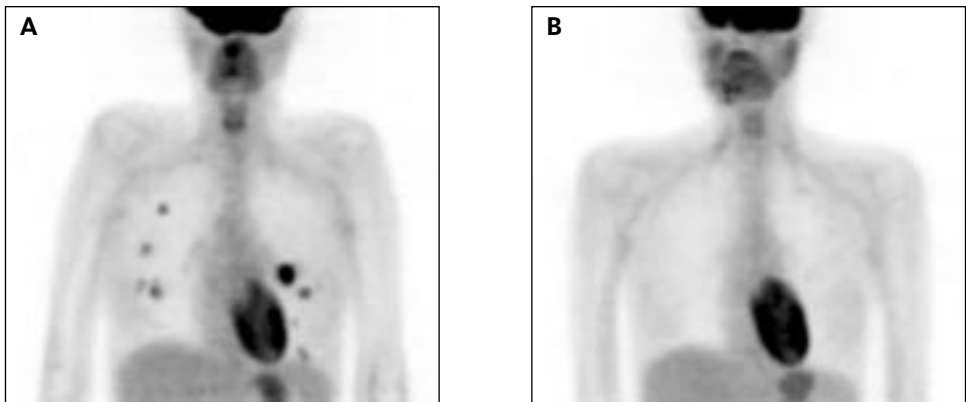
In patient B, positron emission tomography (PET) demonstrated increased uptake of ^{18}F -fluorodeoxyglucose (FDG) in multiple foci in both lungs, suggesting abscesses (Figure 1A). After three months, FDG-PET was normal (Figure 1B).
